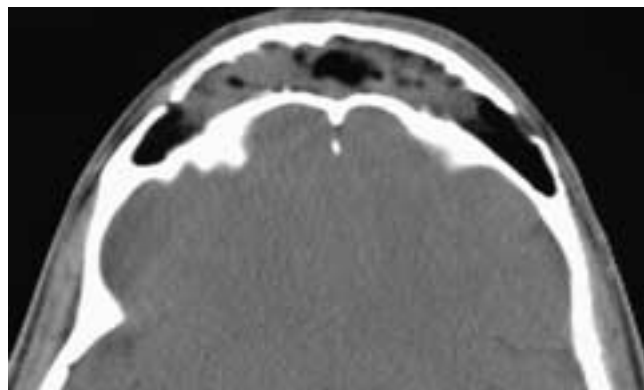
Axial CT scan shows an osteoplastic flap. Although over half of the fat has soft tissue rather than fat attenuation, the bone flap is in a good position and there are no inflammatory changes in the overlying soft tissues. This is a normal imaging variant of this procedure.
